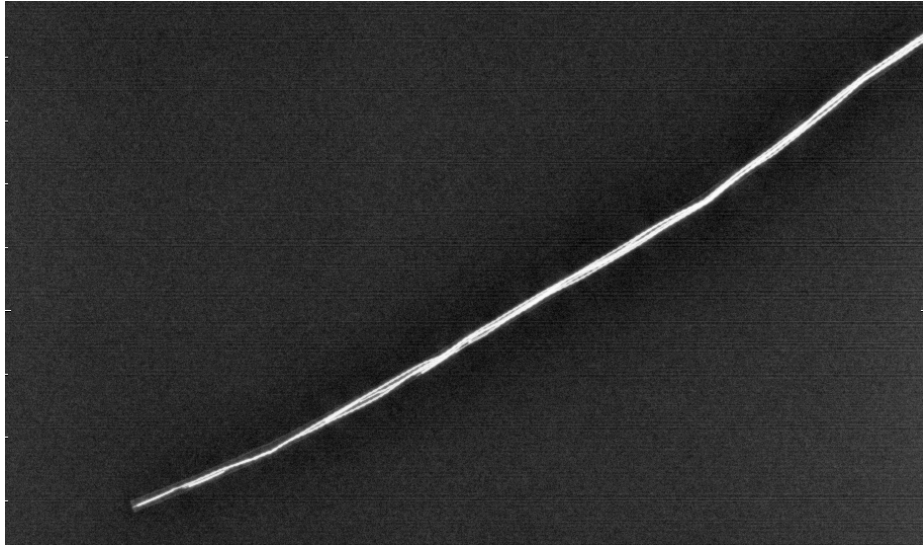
Planar x-ray of shape catheter used for verification of seed placement along the catheter's inner lumen.
